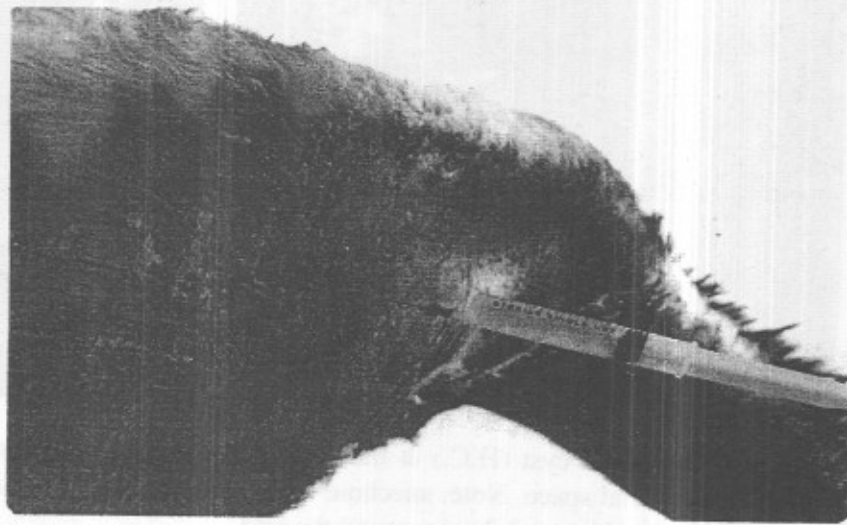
Percutaneous centesis and aspiration of the hepatic hydatid cyst under ultrasonographic guidance. Note the colourless hydatid fluid.
